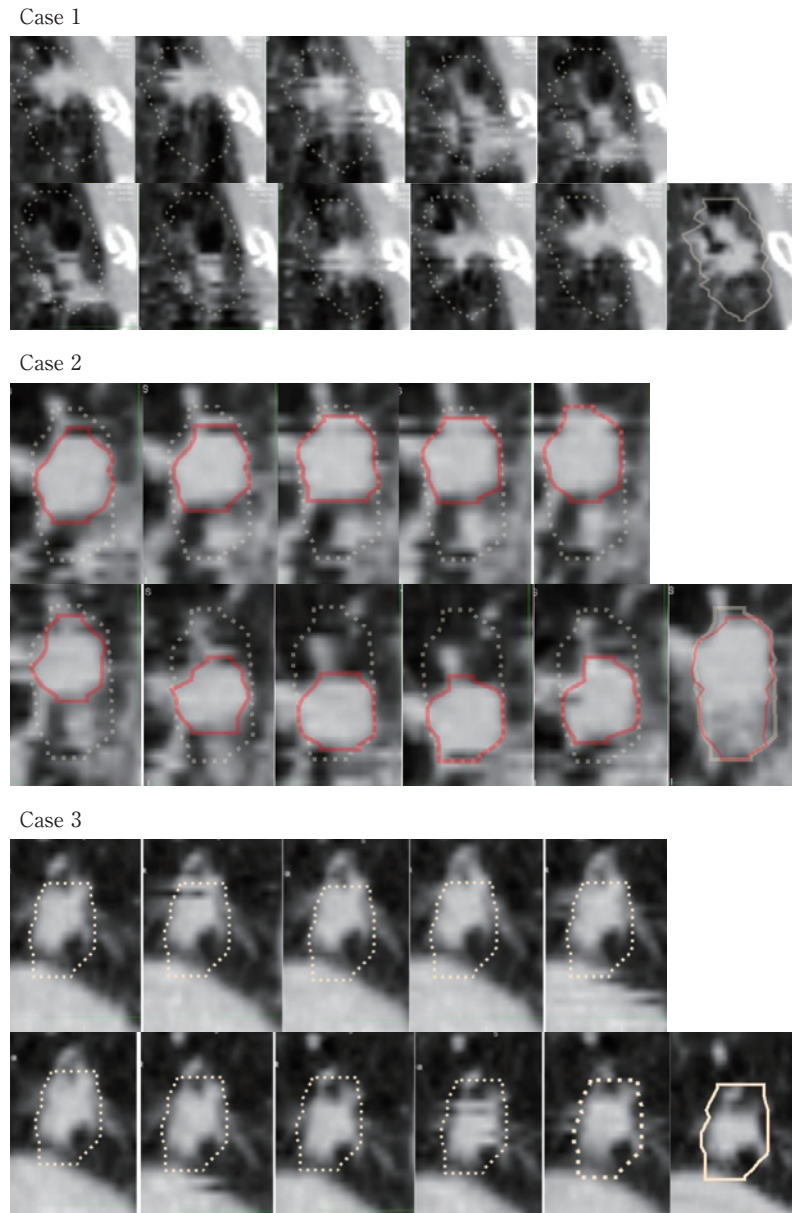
Differences between 3DCT and 4DCT for cases 1 through 3. The upper row shows 5, 15, 25, 35% and 45% of 4DCT, in order, from the left side. The lower row shows 55, 65, 75, 85% and 95% of 4DCT, in order, from the left side. The rightmost image on the lower row shows 3DCT. All CT images are coronal views. The white lines indicate ITV contours. The red lines in case 2 indicate the CTV for each phase.
